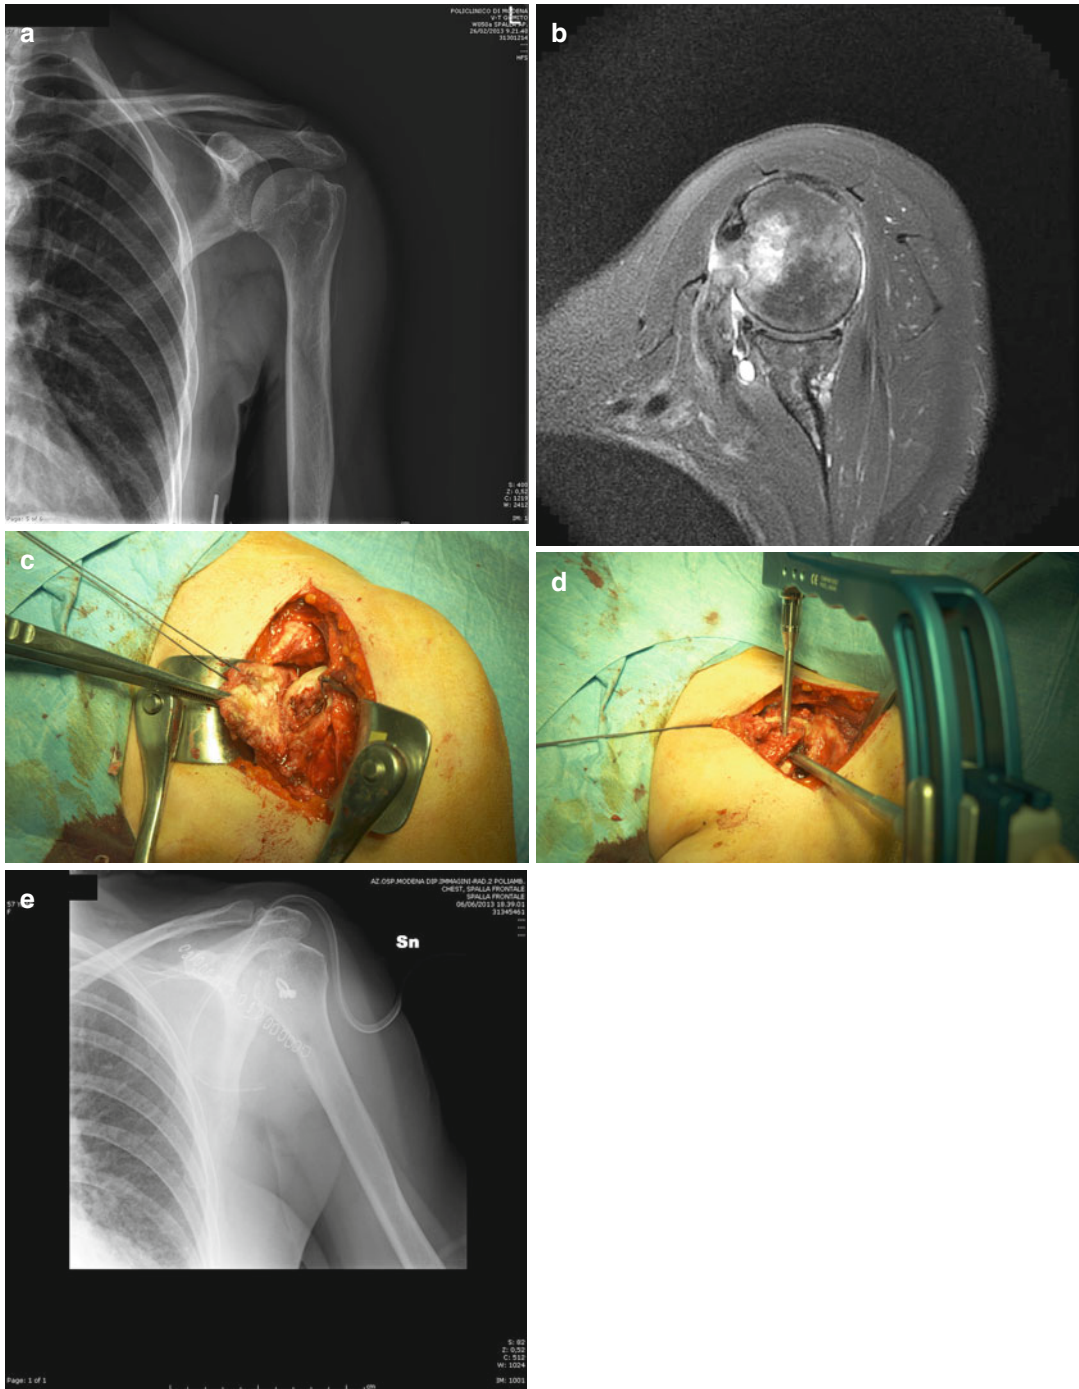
(a) Lesser tuberosity fracture in adult: X-ray. (b) Axial CT fracture view. (c) Bicipital groove preparation as a bed for lesser tuberosity with subscapularis
